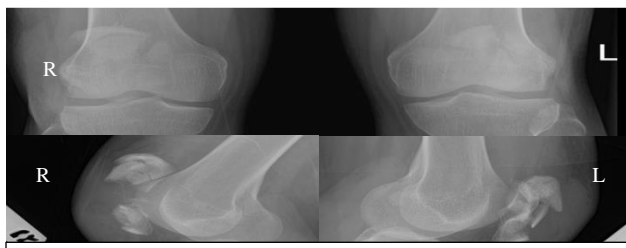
Pre-operative Xray AP & lateral view.
